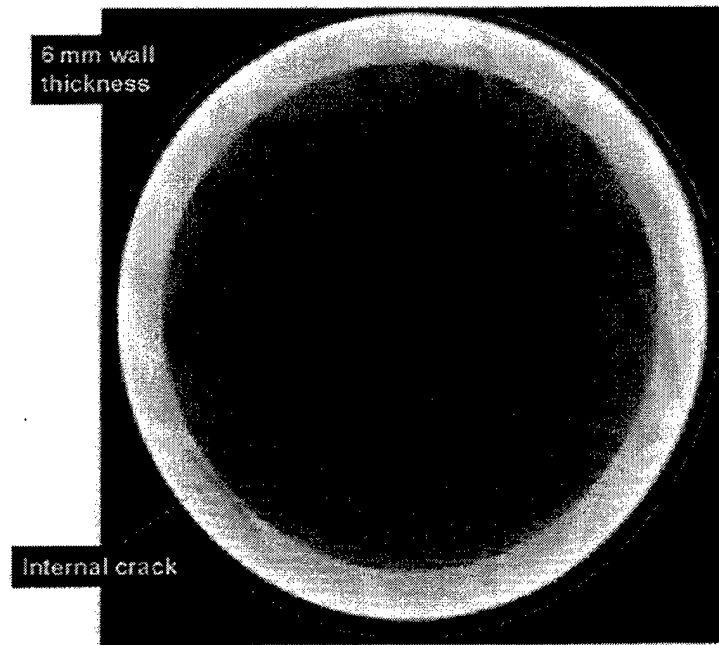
CT slice through the reservoir showing the crack
